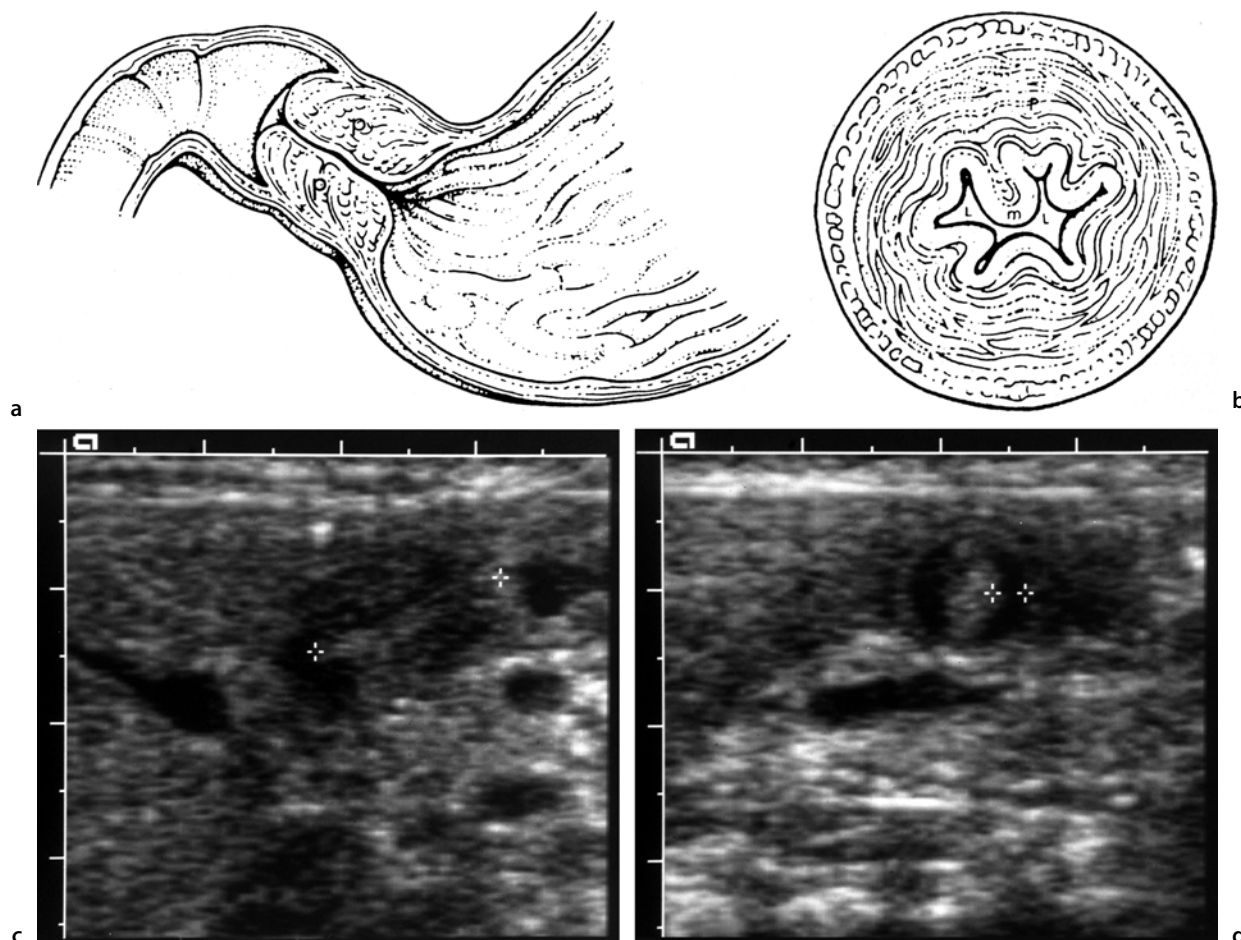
Pyloric stenosis ultrasound diagnosis
